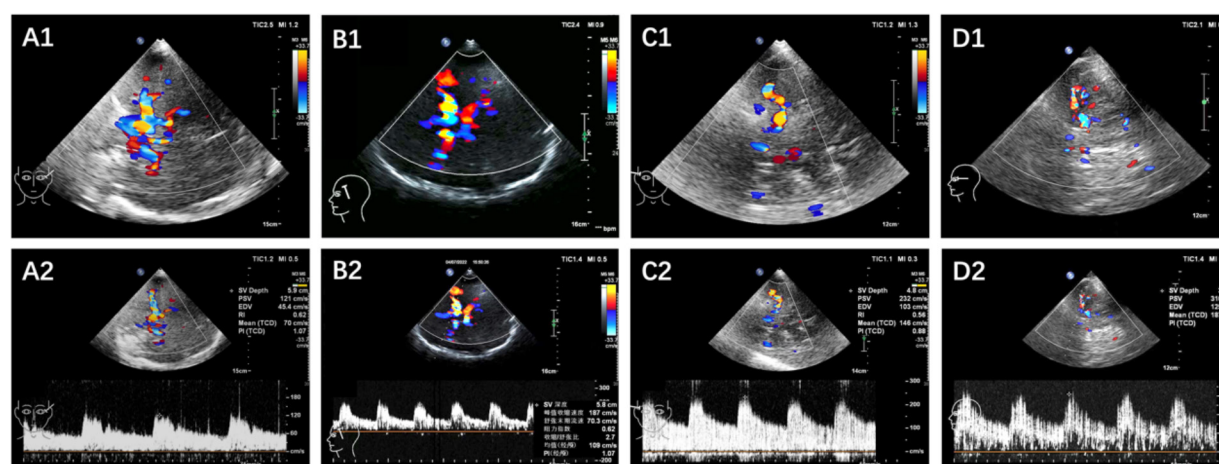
A1, Color Doppler Flow Image showed normal left MCA; A2, Spectral Doppler image showed PSV of approximately 121 cm/s; B1, Color Doppler Flow Image showed mild stenosis in the left MCA; B2, Spectral Doppler image showed a PSV value of approximately 187 cm/s; C1, Color Doppler Flow Image showed moderate stenosis in the right MCA; C2, Spectral Doppler image showed that PSV was approximately 232 cm/s; D1, Color Doppler Flow Image showed severe stenosis in the left MCA; D2, Spectral Doppler image showed that PSV was approximately 310 cm/s.
